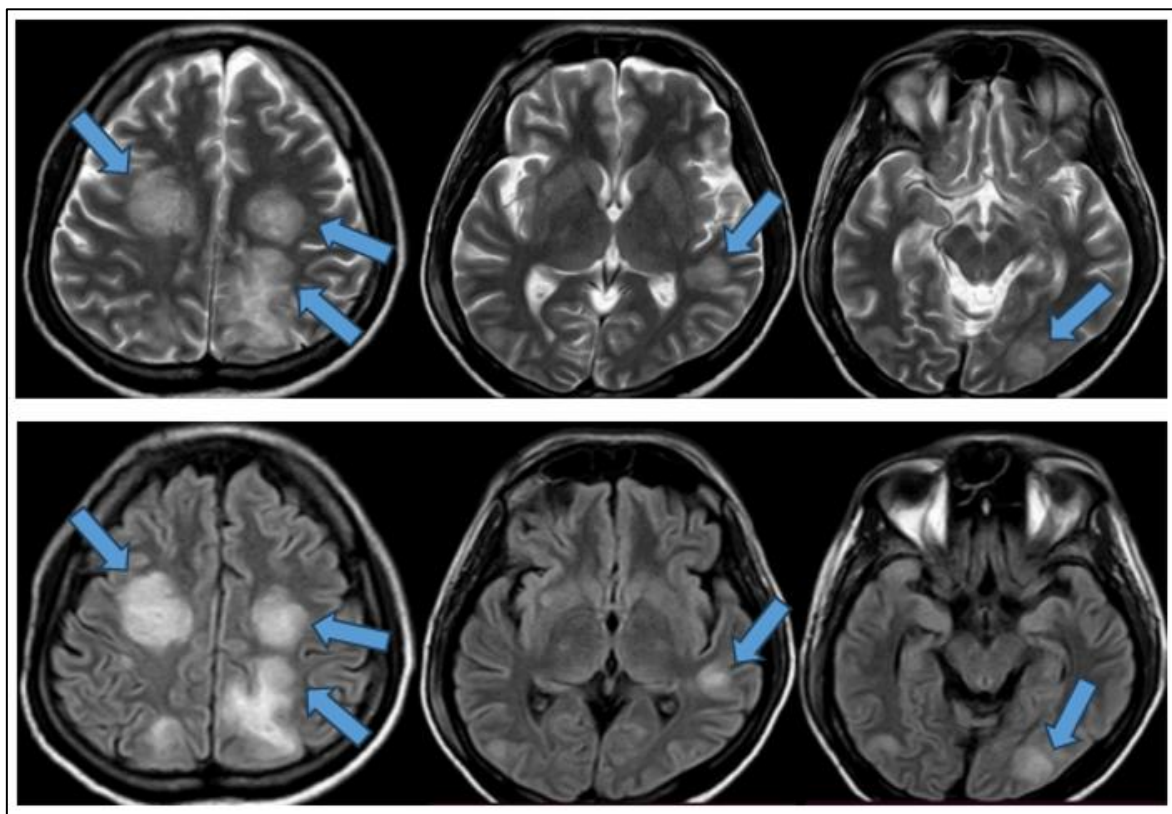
Axial T2 & Fig 1b: Axial FLAIR Sequences Showing Hyperintensities in Centrum Semiovale on Both Sides, Right Anterior Temporal Lobe, Left Temporal and Occipital Lobes Sparing Subcortical U-Fibres.
